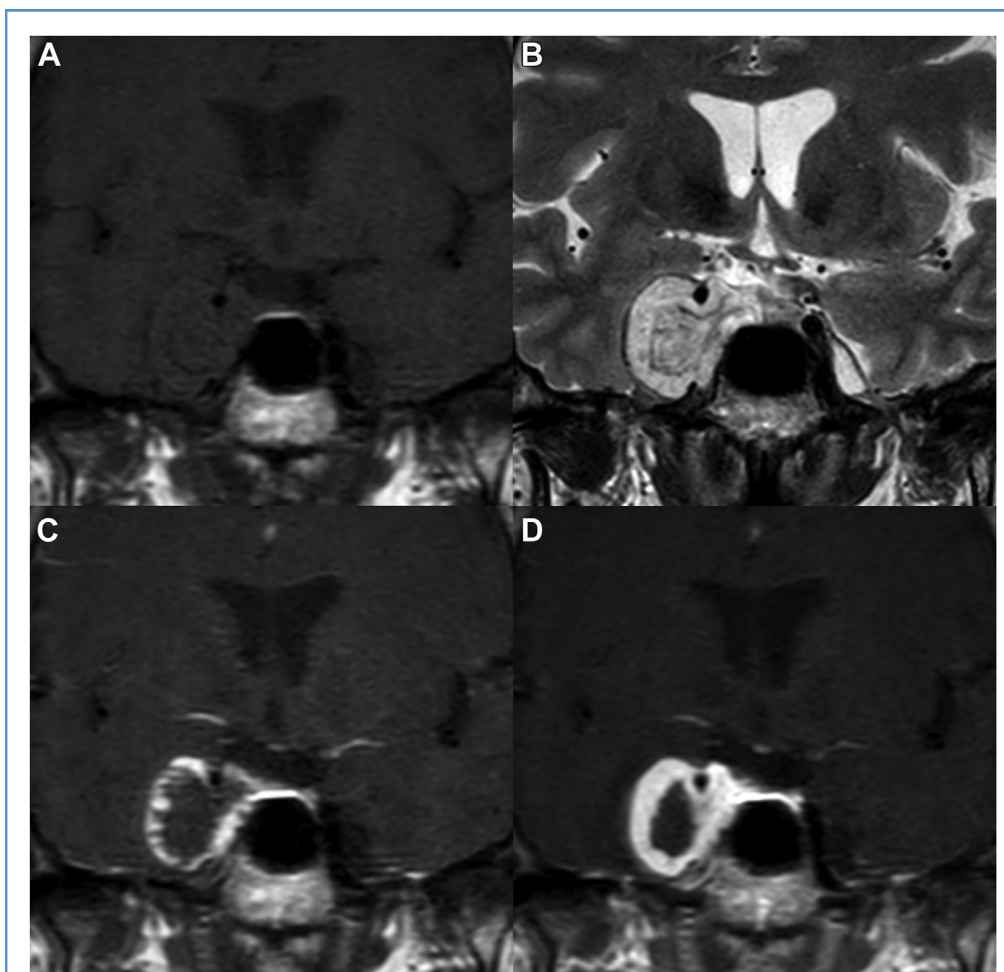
Follow-up radiologic images revealing growth of right cavernous sinus mass extending into the pituitary fossa and Meckel's cave. The lesion was hypointense on T1-weighted image (A) and hyperintense on T2-weighted image (B), with hypointense linear structures within, possible blood
